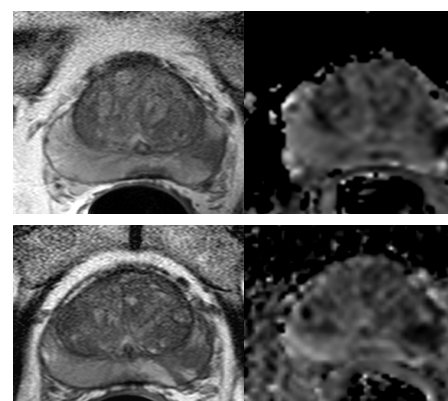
T2W axial (left) & DWI slice (right) at TP1 (top) & TP2 (bottom) in a patient that progressed to radical treatment
